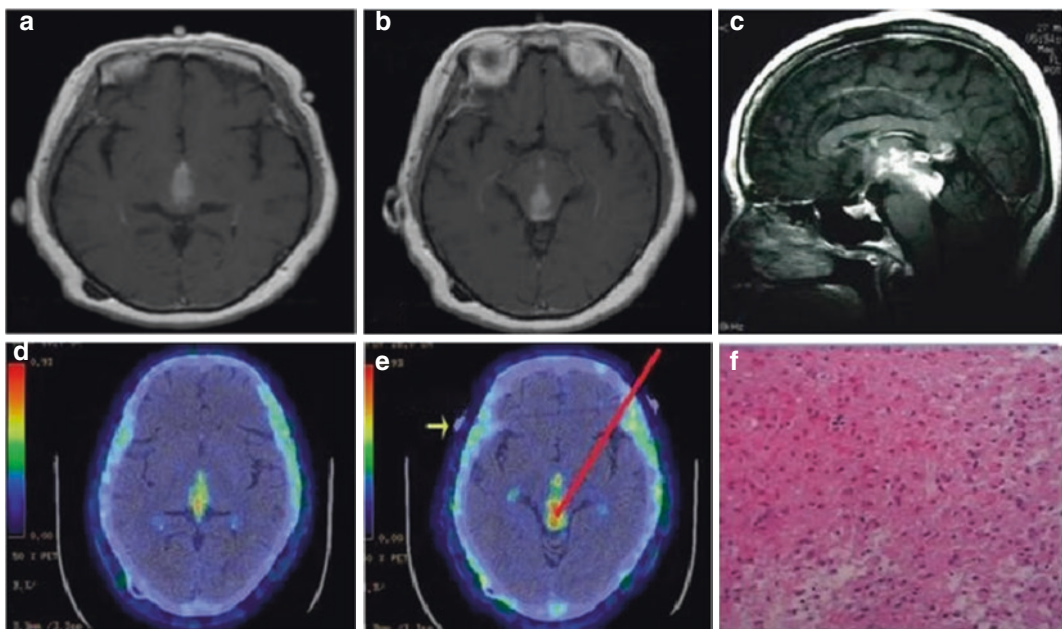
Application of PET in the stereotactic biopsy of gliomas in the pineal gland: Contrast-enhanced T1WI MRI shows significant enhancement in the pineal gland, but uniform signal intensity, which cannot be used to determine the specific status of tumor activity (a–c). MET
